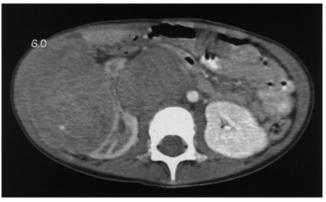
CT image of abdominal neuroblastoma compressing right kidney in nearly 3-y-old child who presented with convulsion from malignant hypertension. Patient is in remission from stage 4 disease 28+ mo later.
